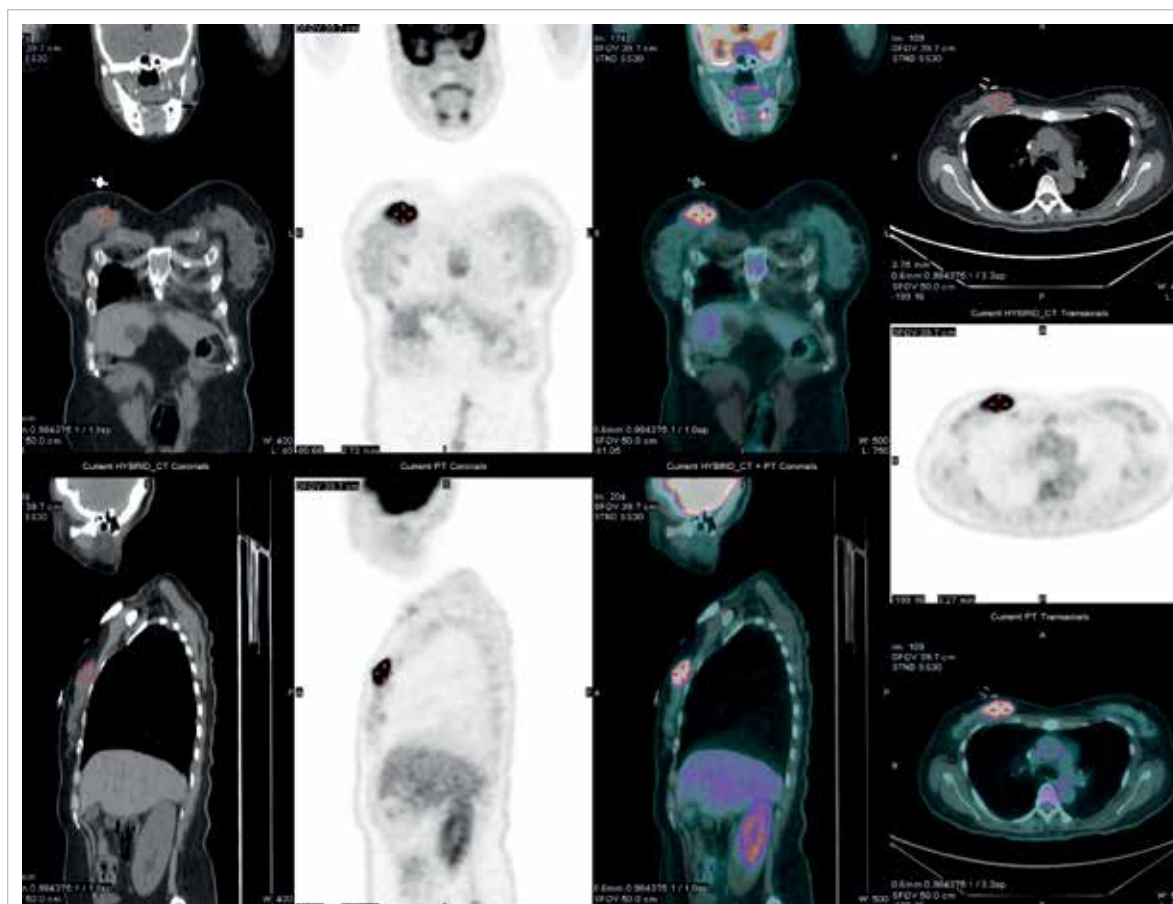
Reassessment positron emission tomography-computed tomography showing enlargement of biopsy-confirmed lymphoma at the upper inner quadrant of the right breast, with increased metabolic activity (maximum standardised uptake value $23.7, 41 \times 21$ mm)
